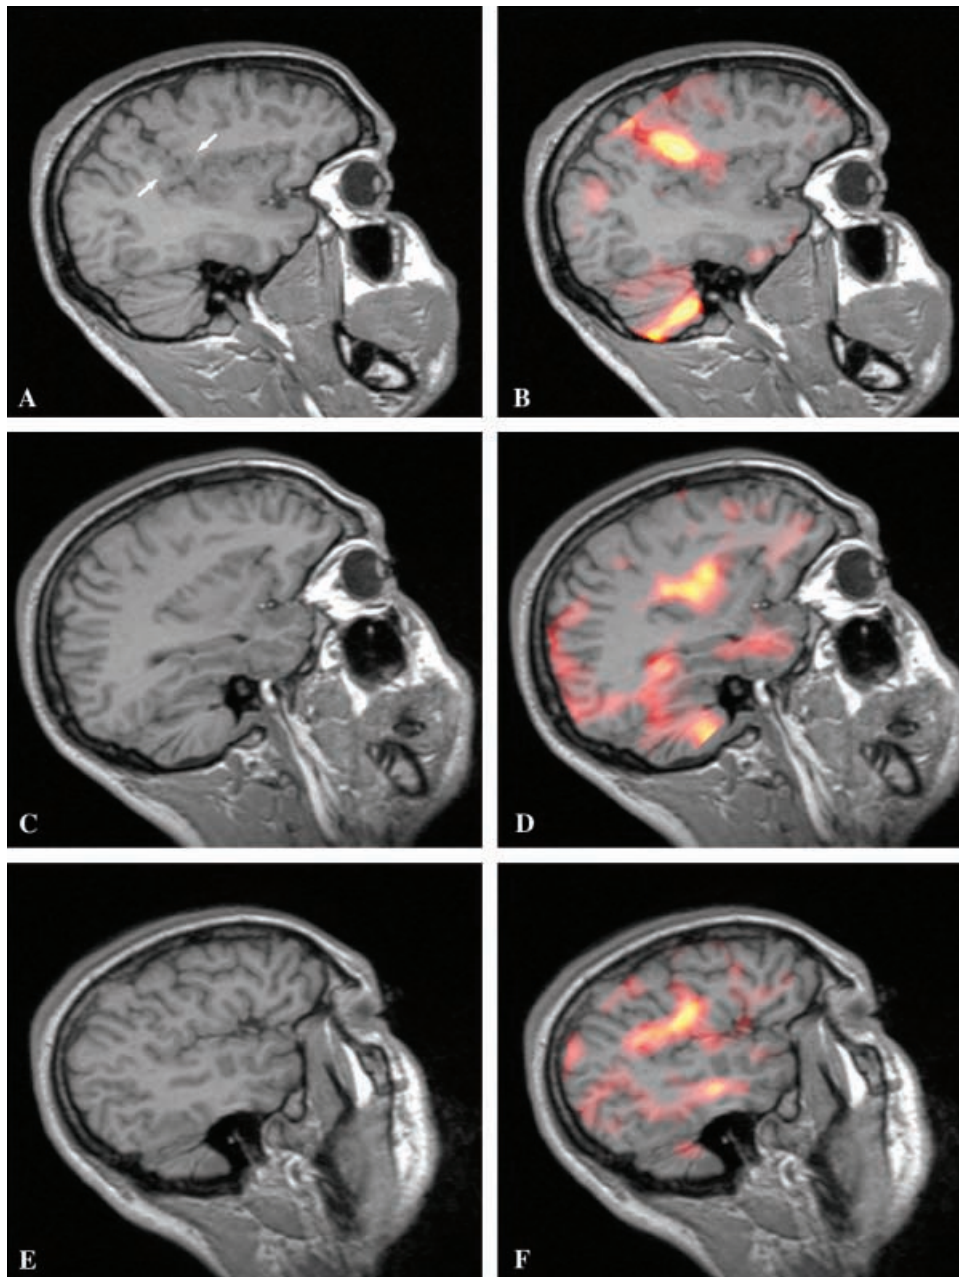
Patient 1 (A, B) and patient 2 (C–F). The sagittal T1-weighted 3D MP-RAGE (Siemens) MR sequence in patient 1 (A) demonstrates the pathological outlining of the left Sylvian fissure, which has multiple small areas of dysplastic gray matter organization mainly irregularly distributed along its course but with a focal concentration of dysplastic cortex at one location (arrows). The SISCOM-image (B) shows a hyperperfusion in the same region. In patient 2 no pathological changes could be identified on conventional MRI (C and E). SISCOM shows opercular and insular hyperperfusion (D and F) shown in sagittal images 31 and 45 mm from the midline).
